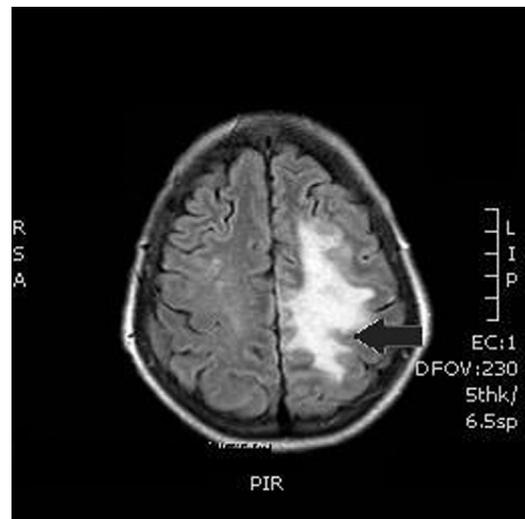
Brain MRI at 48 hours: areas of restricted diffusion suggestive of ischaemic lesions in the left and middle cerebral artery territories (arrow).
